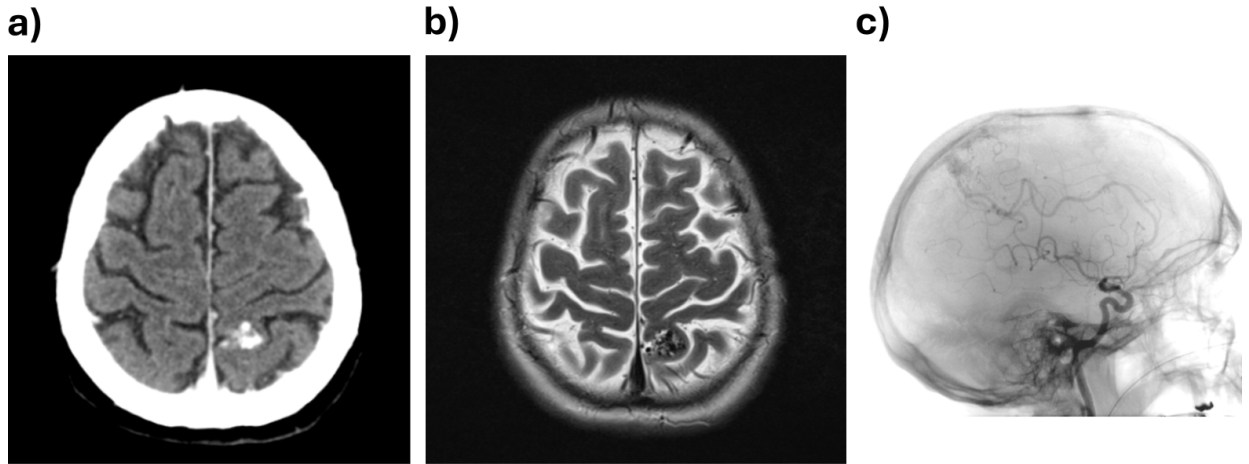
The AVM under investigation for this thesis visualized by various imaging modalities: a) CT, b) MRI, specifically a T2-weighted turbo spin echo image, and c) angiography.
